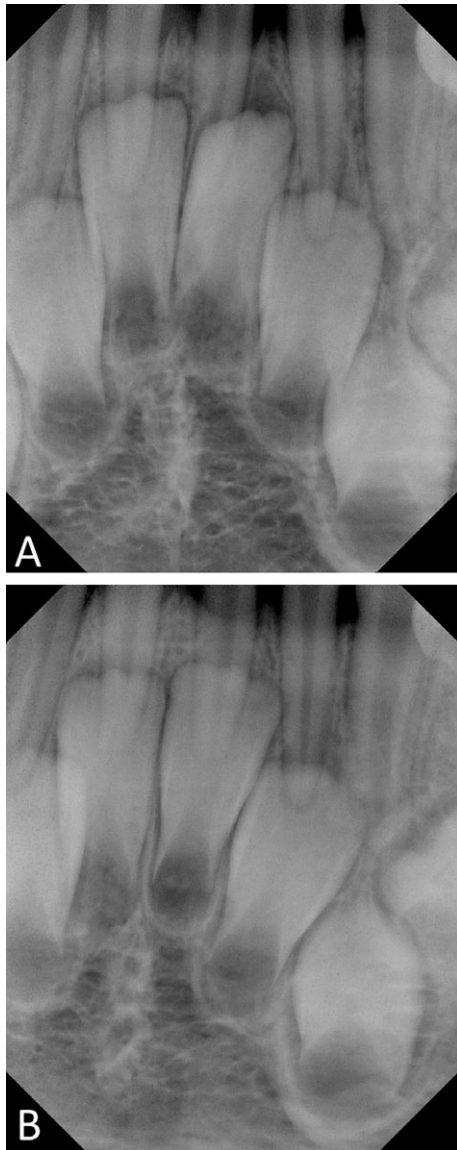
Twins. Showing radiographic evidence of subtle differences in eruption pattern.
